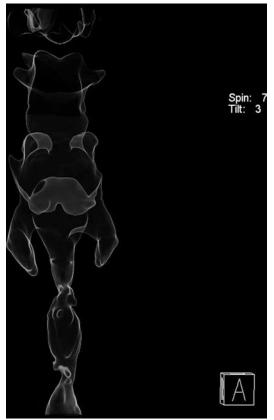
Thoracic CT showing tracheobronchial cartilage stenosis
